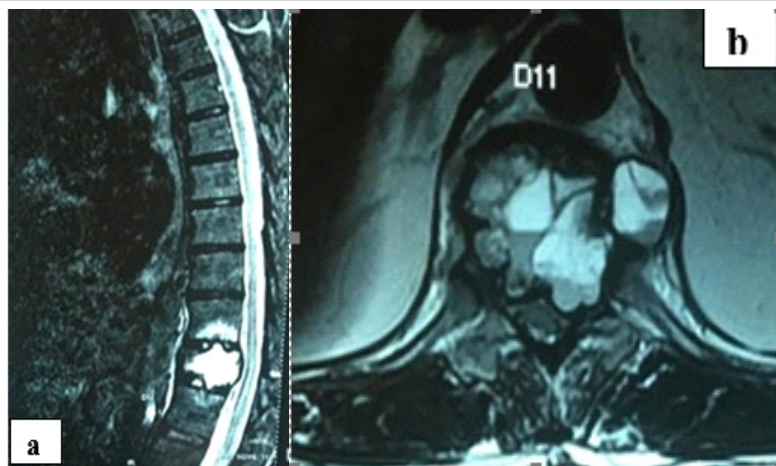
(a and b) T2 weighted sagittal and axial magnetic resonance imaging showing expansile lytic multiloculated peripherally enhancing lesion involving T11 vertebra. Lesion showing multiloculated bubbly appearance with fluid layered locules.
